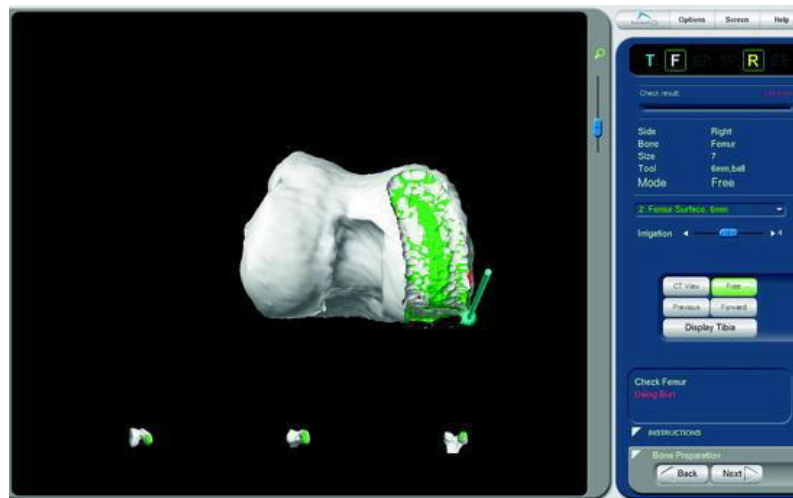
Femoral resection virtual burring environment example. Green is that volume to be resected, white is the bone to remain from the CT model of the femur. The burr position is shown in green/blue in real time. (Hagag et al., 2011)
